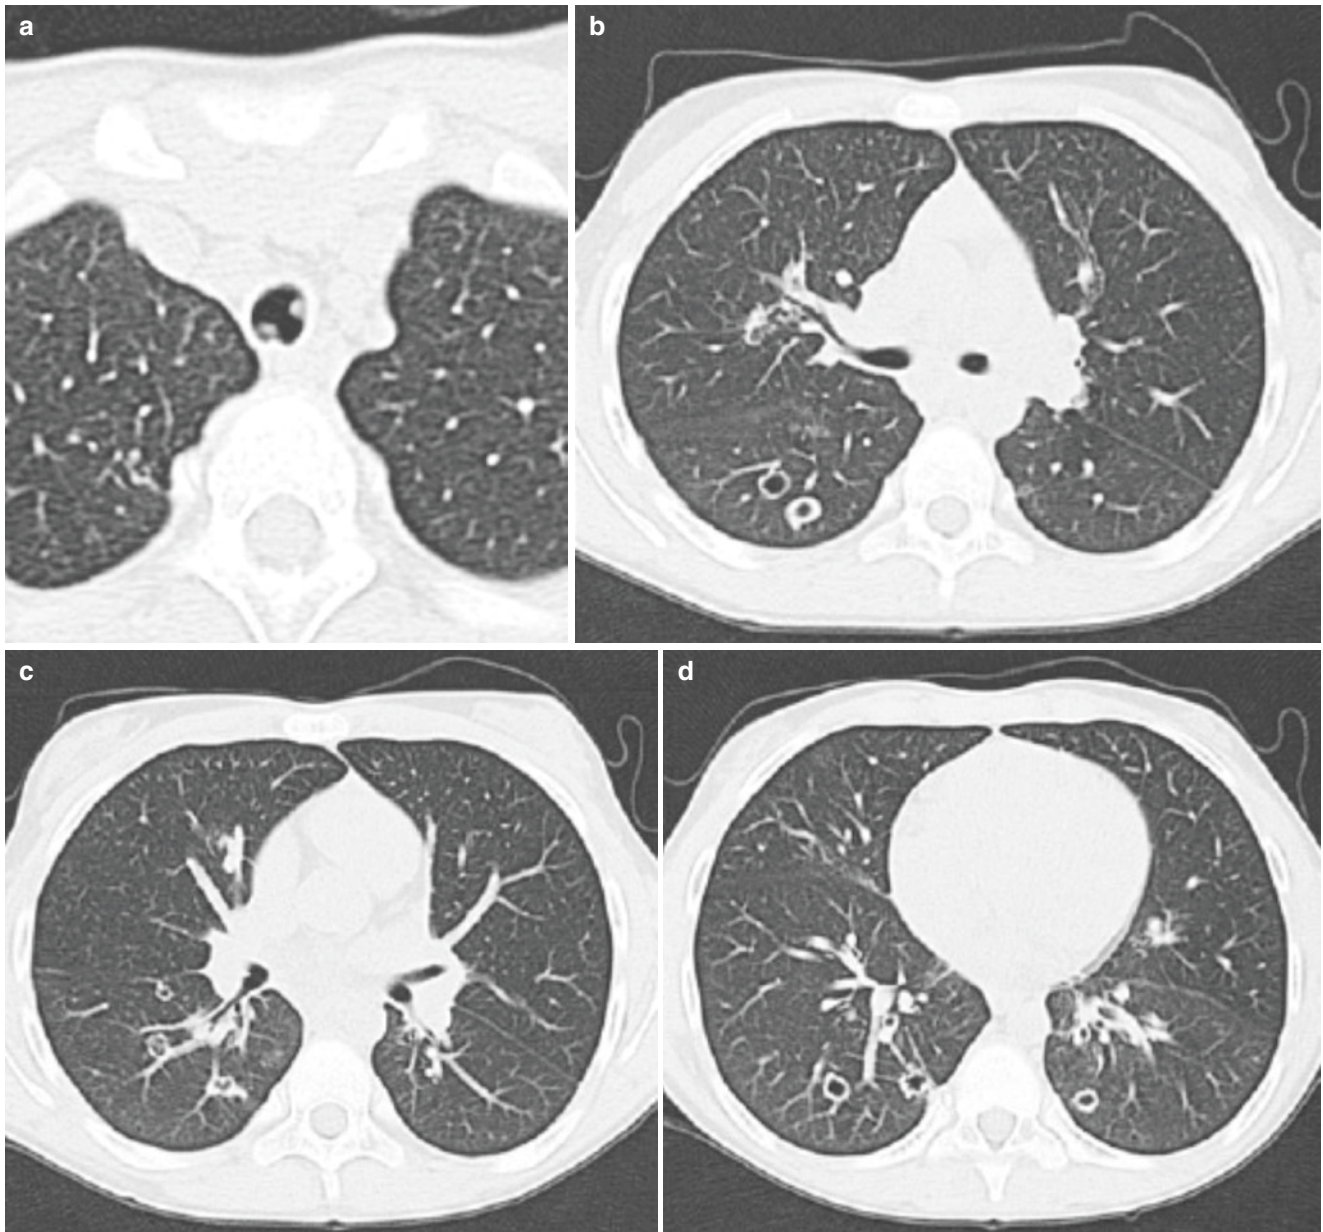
A child with laryngotracheal papillomatosis. Axial lung window CT images (a–d) demonstrate multiple endotracheal soft tissue masses, as well as bilateral cavitary pulmonary nodules, typical for laryngotracheal papillomatosis
